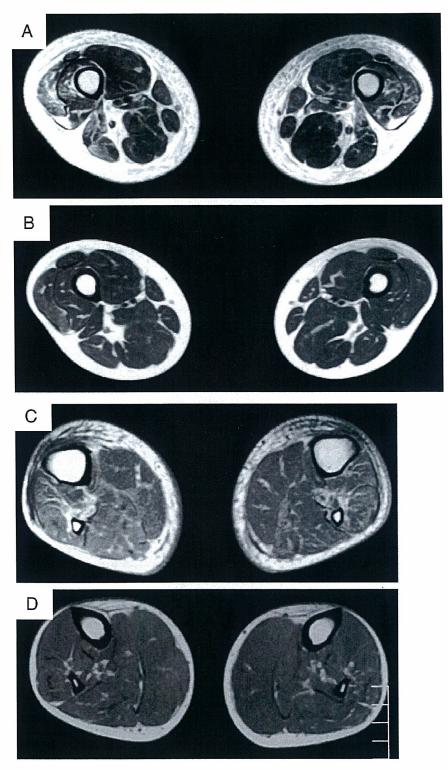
Magnetic resonance imaging (MRI) of lower limb muscles. Before thiamine administration, a T2-weighted image of the middle thigh showed areas of high signal intensity especially in the vastus lateralis and biceps femoris muscles (A). One month later, areas of high signal intensity had disappeared (B). Gd-DTPA-enhanced image of the middle leg before thiamine administration, showing mild enhancement in the tibialis anterior and soleus muscles (C). One month later, no abnormal gadolinium enhancement was seen in these muscles (D).
